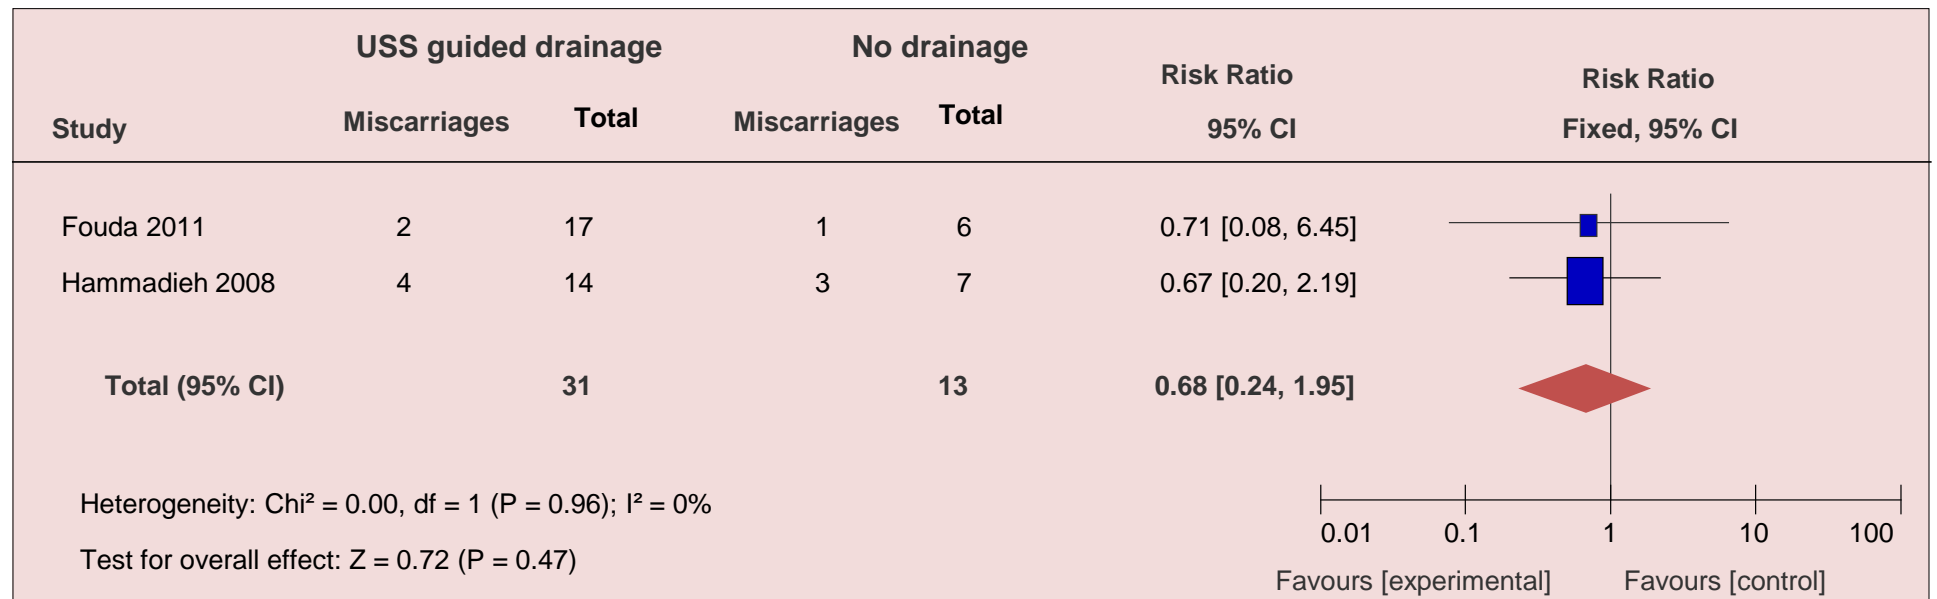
Meta-analysis of randomised studies comparing miscarriage rate in women who had ultrasound guided aspiration for the treatment of hydrosalpinx to women who did not undergo treatment for hydrosalpinx
